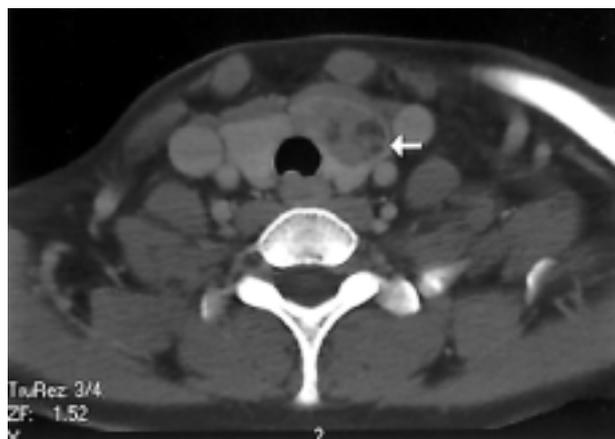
Radiographic finding. Computed tomography demonstrates a 2.6×1.6×2.4cm-sized well-demarcated nodule with mixed radiodensity on the left lobe of the thyroid (white arrow).
